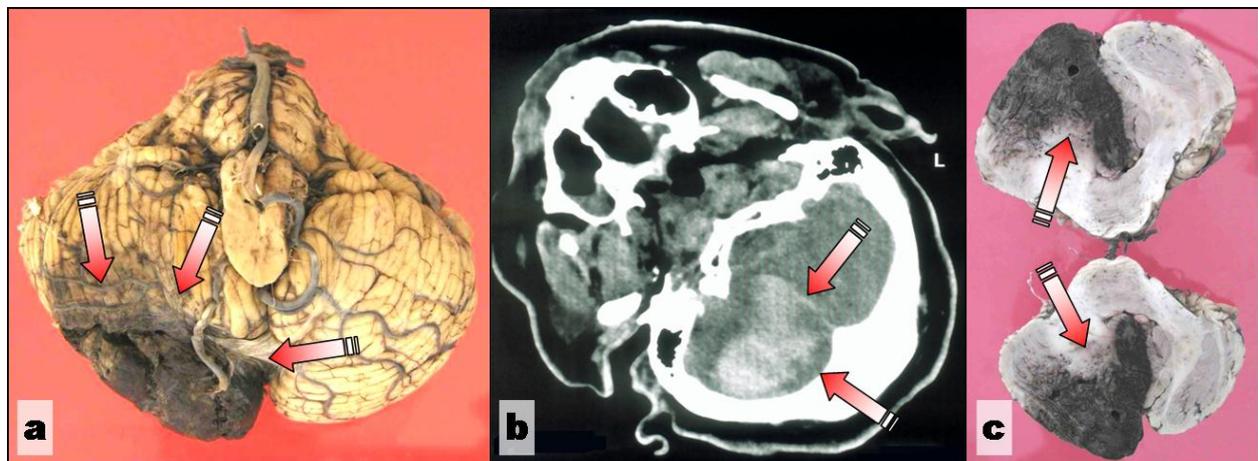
Right side cerebellar hematoma: (a) Necropsy gross aspect – caudal view; (b) CT aspect; (c) Necropsy gross aspect on transverse section.
